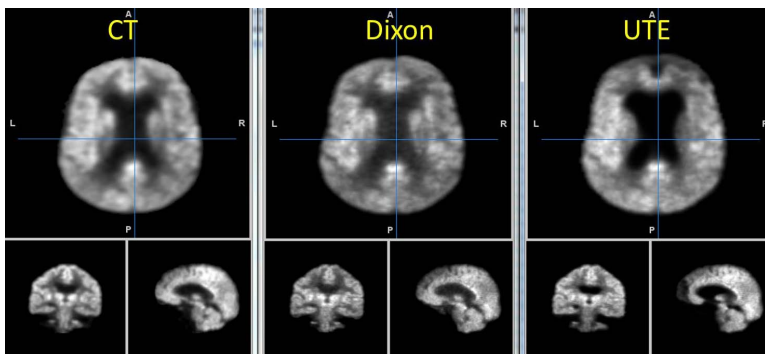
PET corrected with CT-, Dixon- and UTE-based attenuation correction demonstrate similar uptake patterns.
